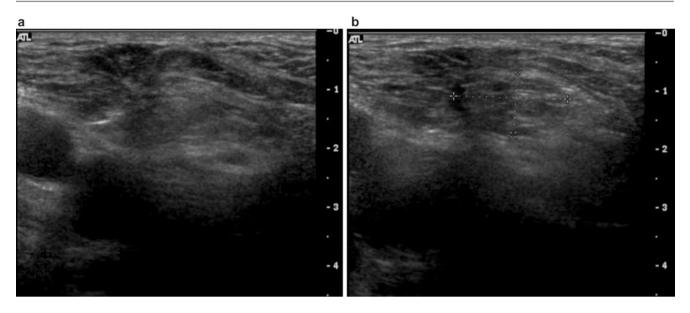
Ultrasound of right inguinal hernia in transverse plane (a) at rest and (b) with valsalva
